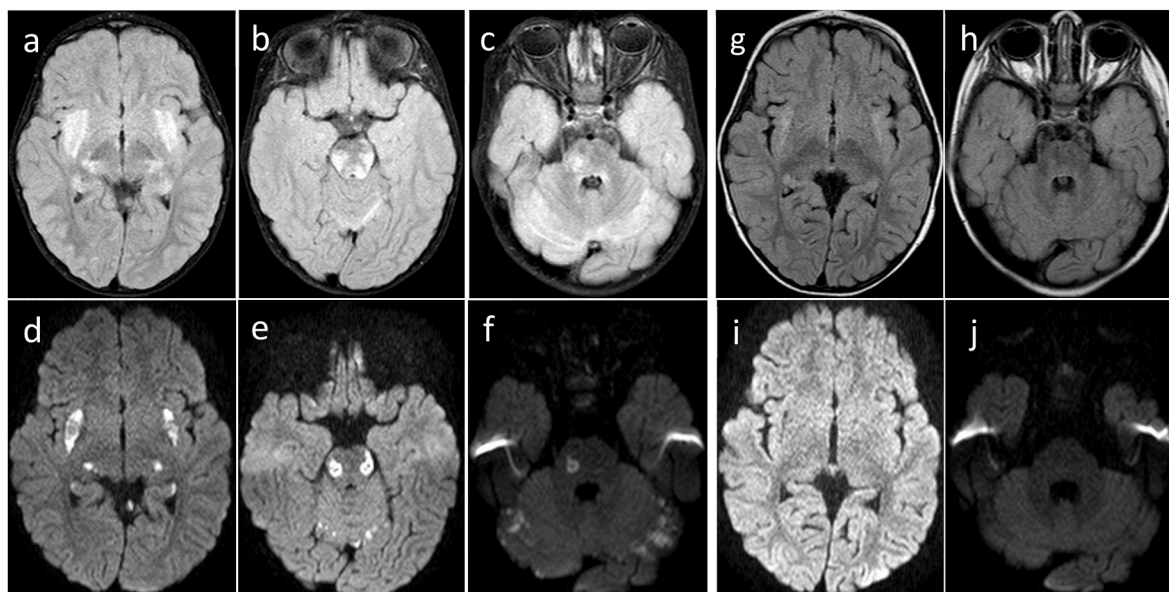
MRI study at patient's first episode (age 2 years). FLAIR-STIR areas (a,b,c) of hyperintensity involving external capsules, cerebellar cortex and pons with restricted diffusion on DWI (d,e,f); MRI hyperintensity reduction in FLAIR-STIR (g, h), without restricted diffusion on DWI (i,j) at day 22 after symptoms onset.
